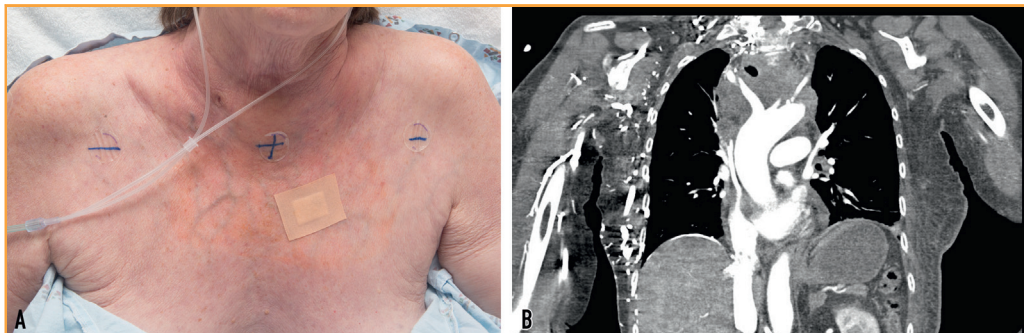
Superior vena cava syndrome in a patient with a large malignant mediastinal mass. A, Extensive venous collaterals can be seen on the right side of the chest wall and the right arm. B, Computed tomogram shows dilated superficial veins in the anterior chest wall.
